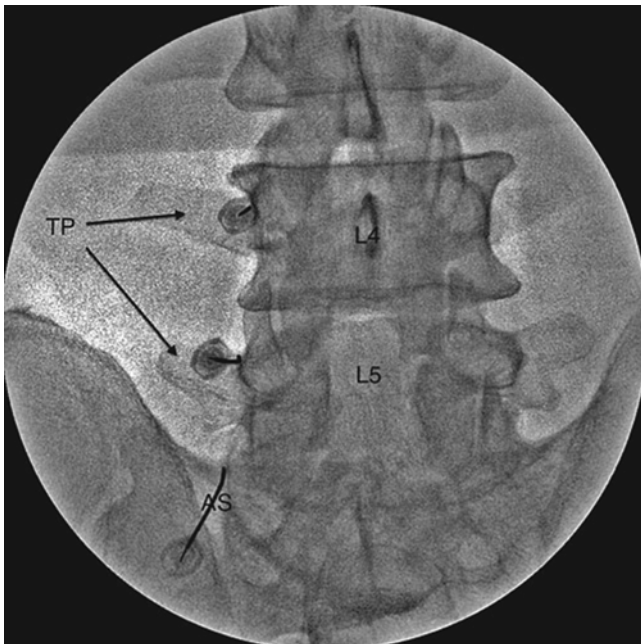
Anterior-posterior radiograph of needle placement for lumbar medial branch RF procedure. *TP* transverse process of vertebral body, *AS* ala of sacrum, *L4* L4 vertebral body, *L5* L5 vertebral body
